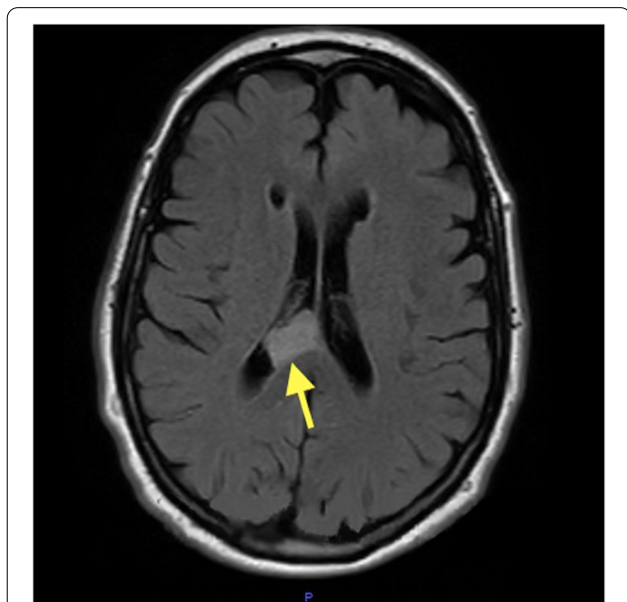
T2-weighted MRI image of the brain showing a subependymal tumour in the right lateral ventricle
